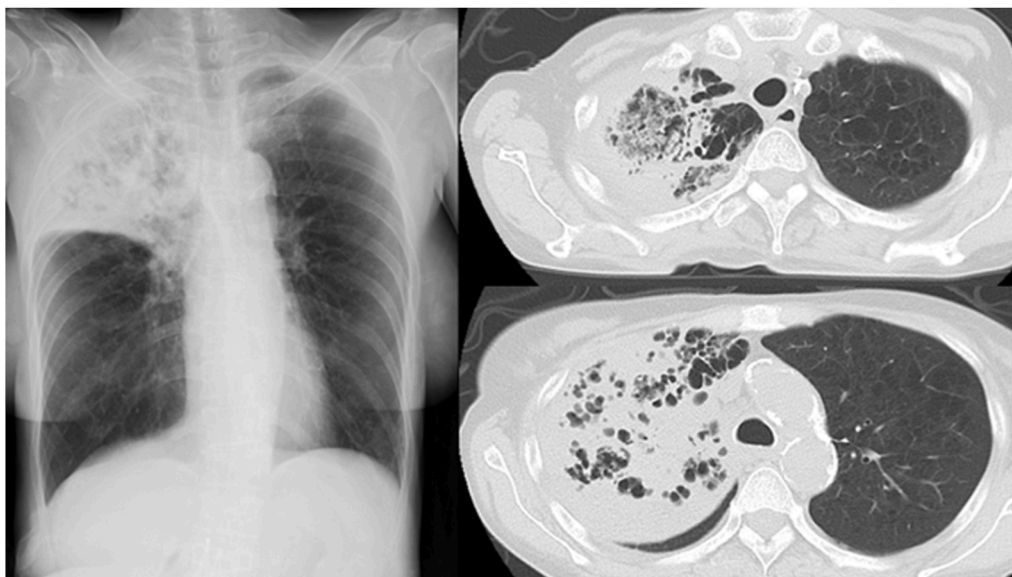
Chest X-ray examination on admission showed infiltration in the right upper lobe field. Chest computed tomography on admission showed an infiltration shadow with air bubbles in the right upper lobe and severe emphysema in the left lobes.
